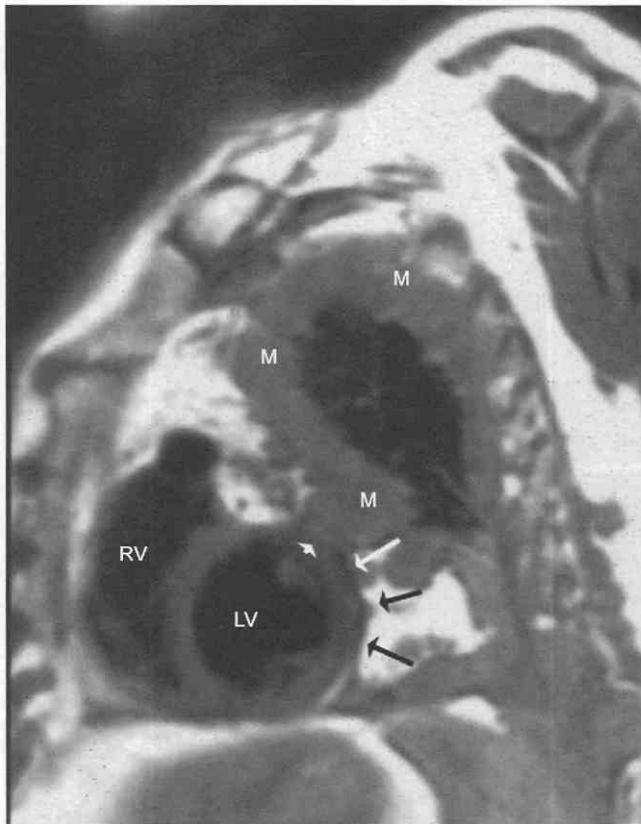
MR image of a left pleural mesothelioma in a 66-year-old man. Oblique sagittal spin-echo acquisition shows the markedly thickened pleural mass (M), with thickening of the pericardium (arrows) surrounding the posterior left ventricle (LV). There is a break in the pericardium (arrowhead) where the mass has penetrated to the left ventricular myocardium. RV, right ventricle.
